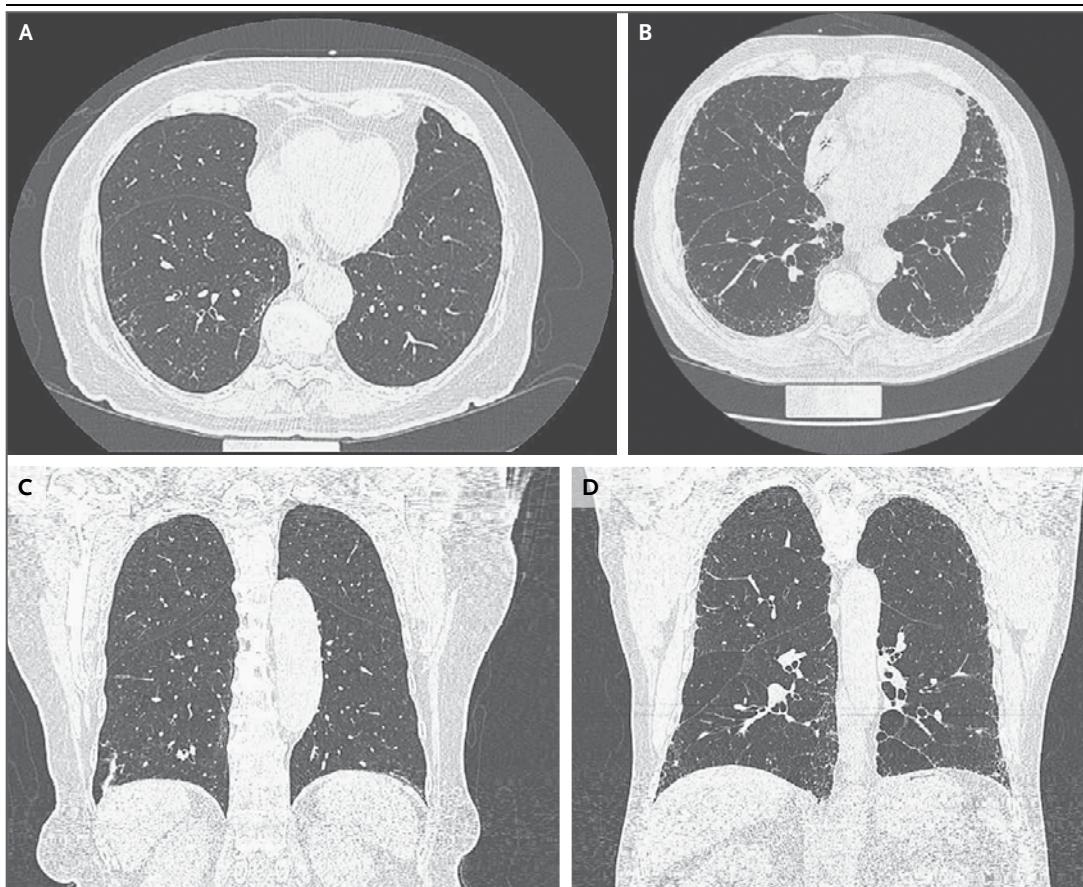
Computed Tomographic Images of Two Participants with Lung Abnormalities.
